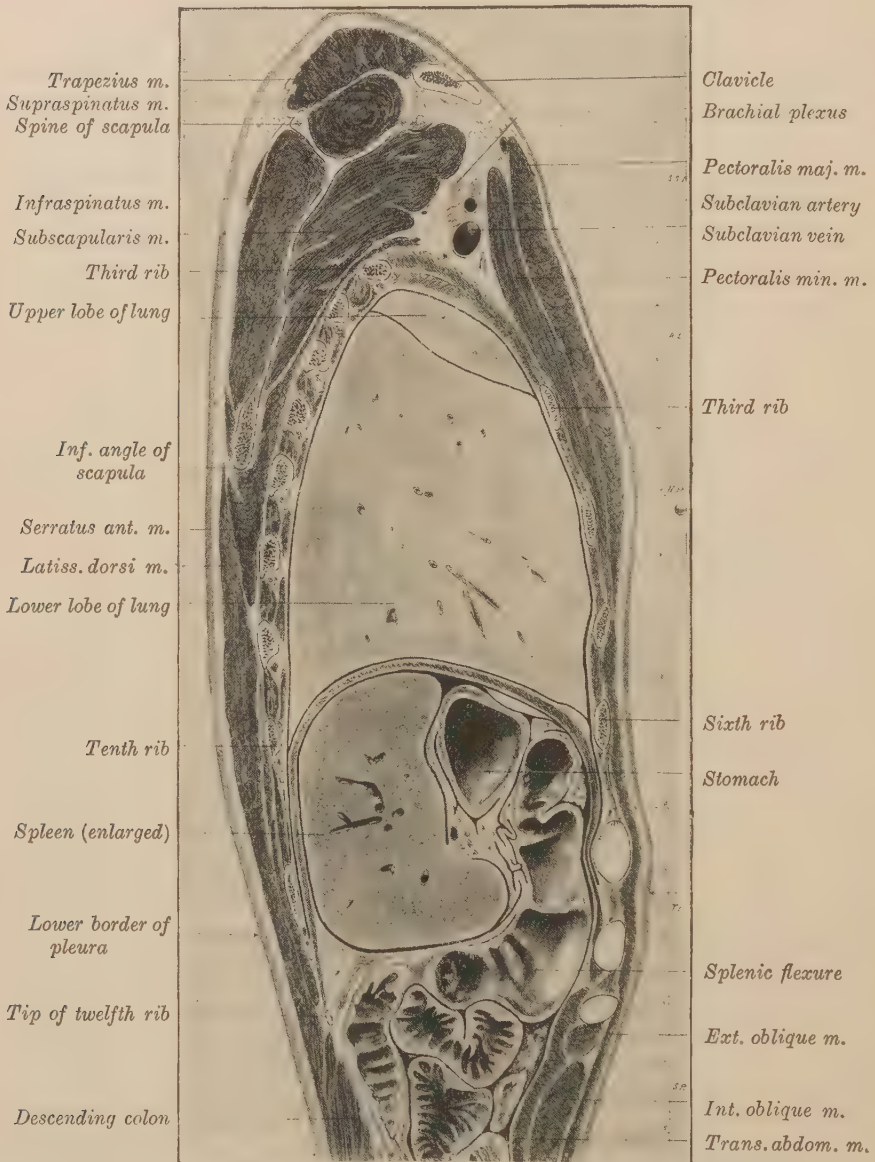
SAGITTAL SECTION OF THE TRUNK OF A MAN AGED FORTY YEARS, MADE ABOUT 10 CM. TO THE LEFT OF THE MEDIAN PLANE, VIEWED FROM THE MEDIAN ASPECT. One-third natural size. (J. S. Dickey.)
